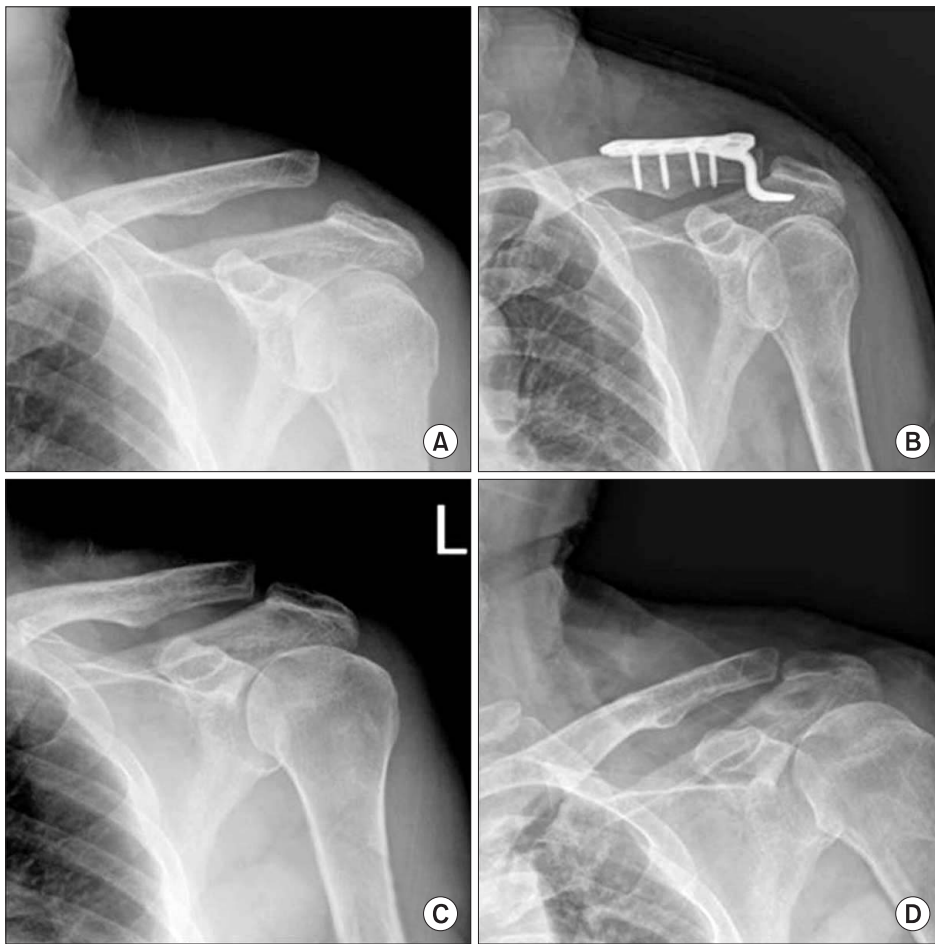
A 50-year-old male with left shoulder pain due to slip down injury. (A) Initial simple radiograph showing an acromioclavicular joint dislocation (type V). (B) The patient underwent surgery using AO hook locking plate on the third day of injury. (C) The AO hook locking plate was removed at 7 months after the initial surgery. (D) Radiograph taken at 19 months after the initial surgery.
